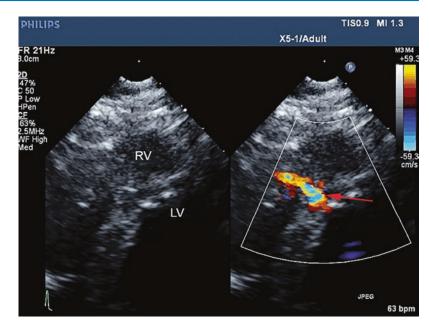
Parasternal short-axis view at a basal level with color flow Doppler demonstrating a perimembranous VSD (*red arrow*). *RV* right ventricle, *RA* right atrium, *LVOT* left ventricular outflow tract
